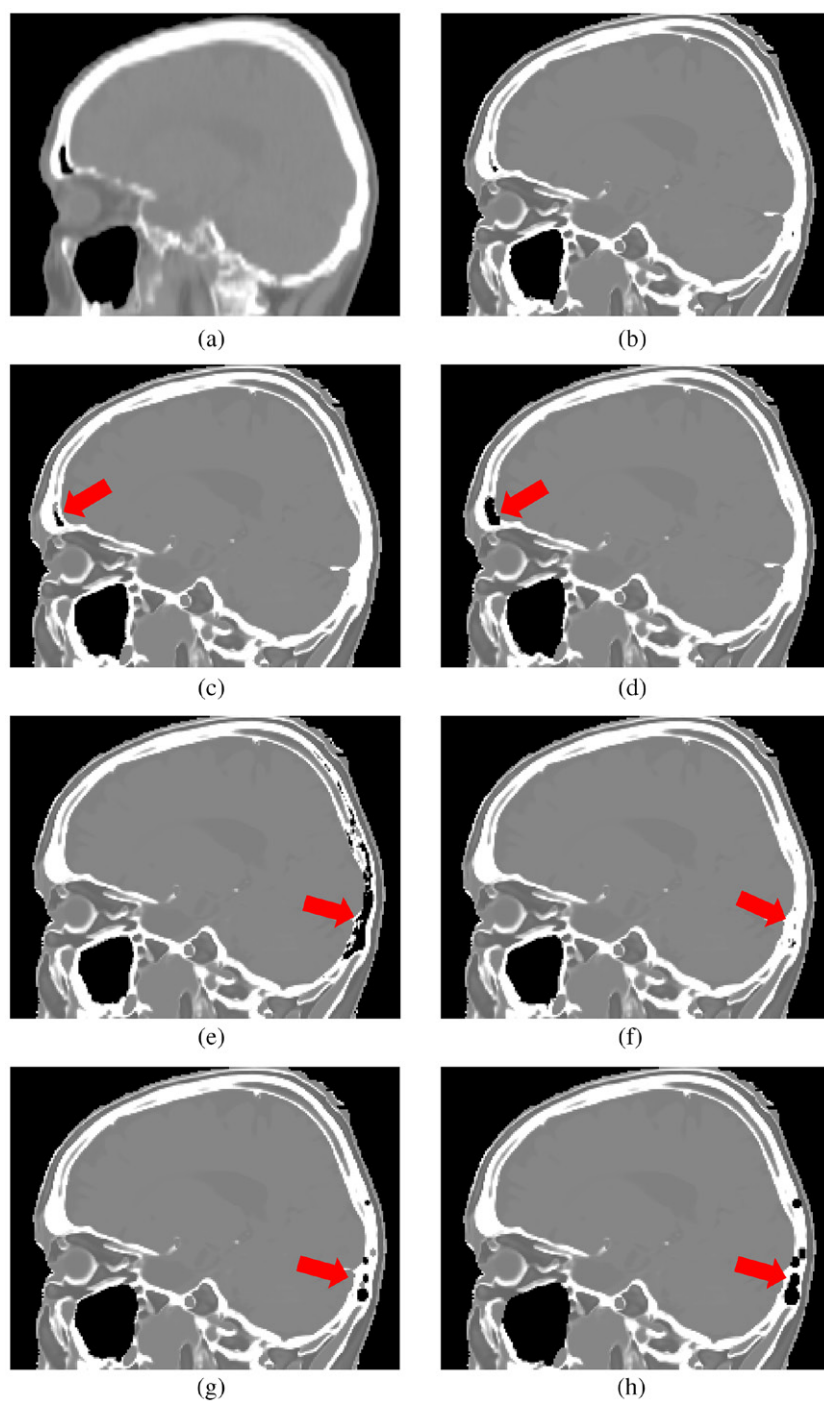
(a) CT and (b)–(h) synthetic CT from seven different air masks generated by: (b) UTE images, (c) bias-corrected UTE images, (d) bias-corrected UTE images with a 1 mm expansion, (e) PETRA images, (f) bias-corrected PETRA images, (g) bias-corrected PETRA images with a 1 mm expansion, and (h) bias-corrected PETRA images with a 2 mm expansion.
